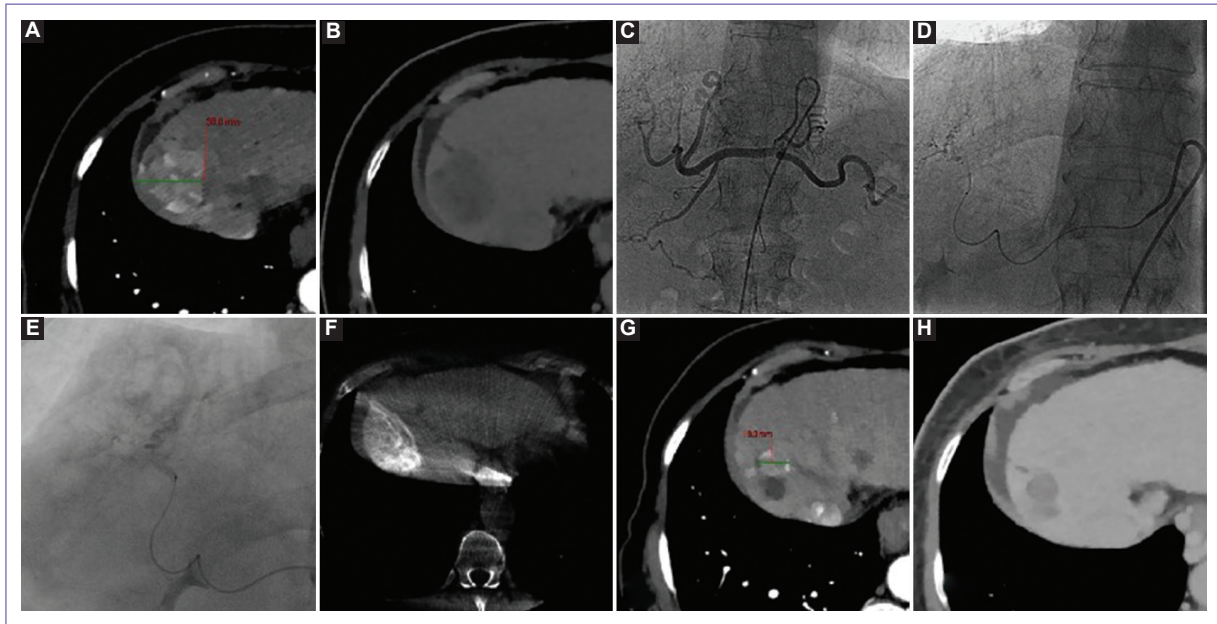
Case no. 5, transarterial embolization (TAE) and post TAE changes at the 1st month, with partial response (PR) according to mRECIST. A and B: contrast images in axial, arterial and venous phase, compatible with LIRADS 5 lesion in segment 7-8 with 39 mm diameter in axial. C: cannulation and selective angiography of the celiac trunk with a Simmons angiographic catheter. D: supraselective catheterization of the common, proper, and right hepatic arteries and segmental branches of the lesion in segment 7-8. E: nodular or “tumor Blush” enhancement of the lesion to be embolized (white arrow). F: axial CBCT corroborates the selectivity of the territory to be embolized (white arrow). G and H: postTAE changes in axial, arterial and venous phase, in relation to LIRADS-viable, PR, residual lesion measures 18 mm in axial, decreased 50%.
